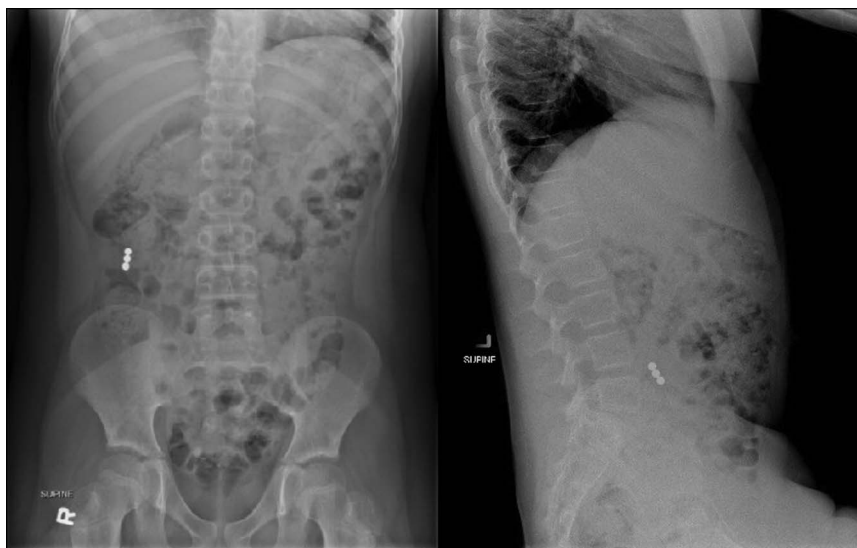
Anteroposterior and lateral abdominal x-ray showing foreign bodies located within the right midabdomen.
